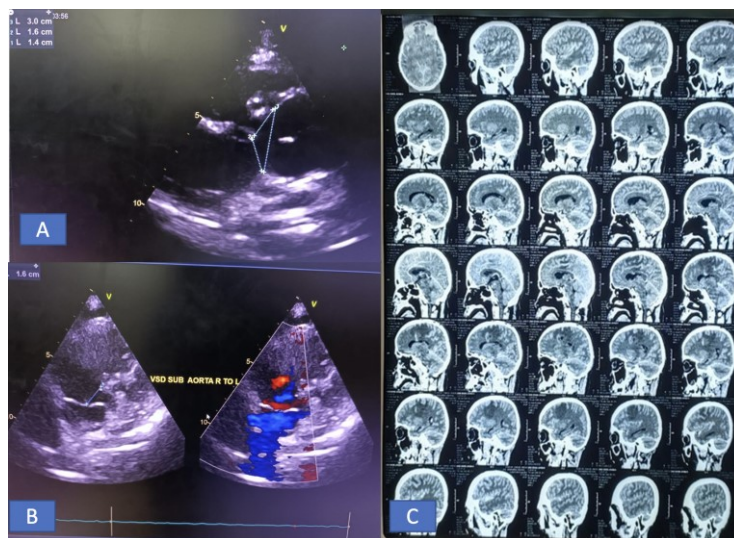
A. Overriding aorta B. 2 VSD Subaortic C. CT Scan Showed Brain Abscess in Left Parietal
